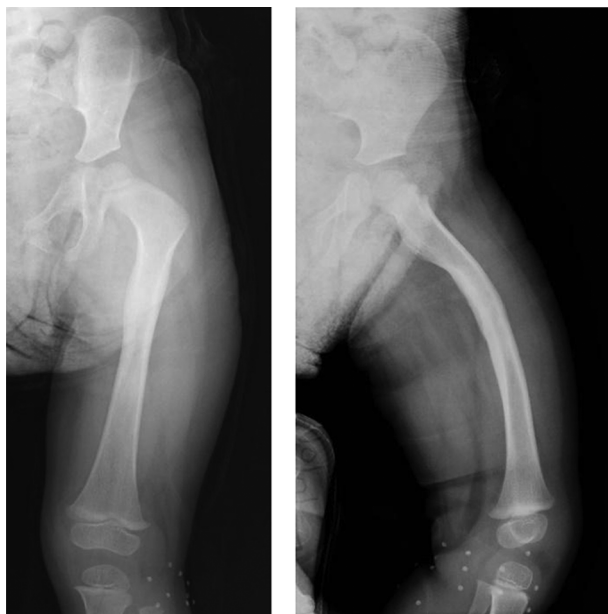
Radiograph Shows Remodeling of the Femur After 24 Months
